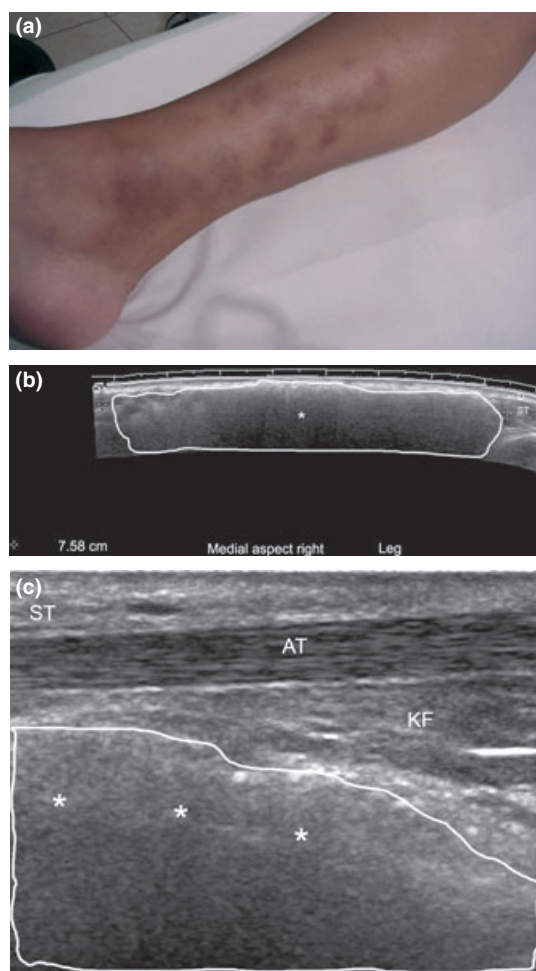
Silicone oil dermatopathy. (a) Morphea-like reaction in the leg. (b) Ultrasound of the medial aspect of the leg (longitudinal view) shows hyperechoic deposits predominating in the subcutaneous tissue (within the white line). (c) Ultrasound (longitudinal view): Silicone oil fills the Kager's fat pad in the posterior ankle (below the Achilles tendon, within the white line). ST, subcutaneous tissue; AT, Achilles tendon; KF, Kager's fat pad; *Silicone oil deposits.
